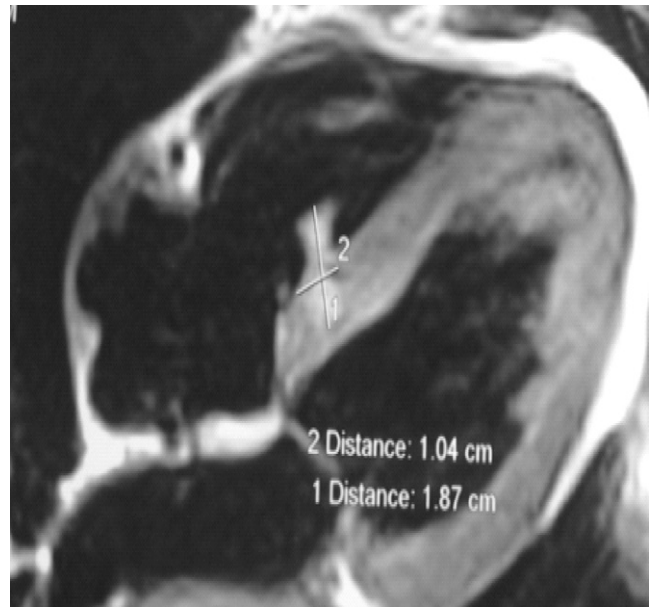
Magnetic resonance imaging revealing thickened needle.
